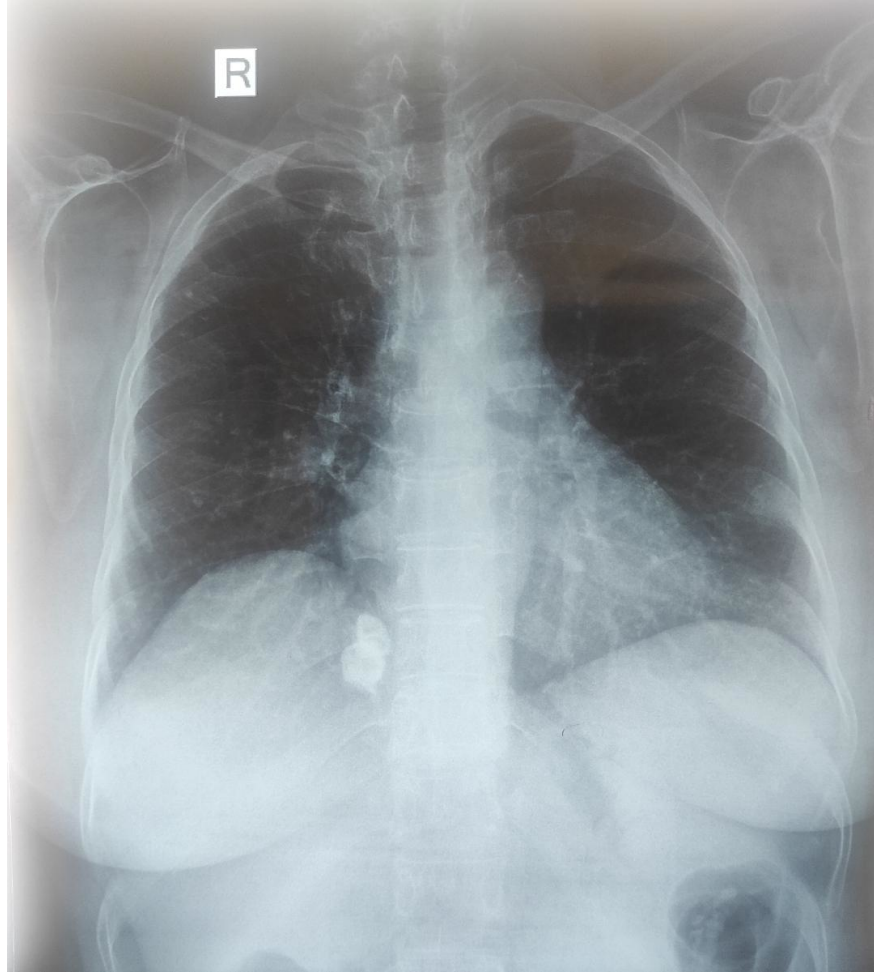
Repeat Chest xray PA view taken on follow up visit. No progression of the disease condition.
